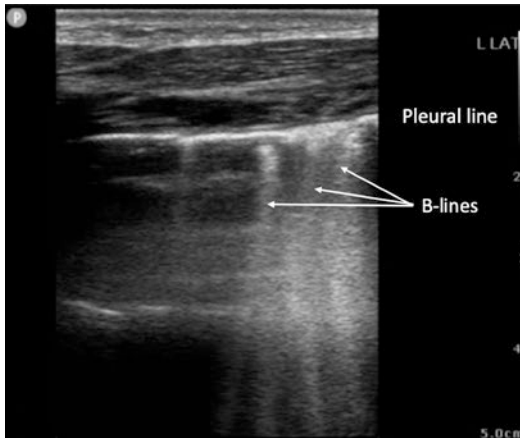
Linear probe 2D ultrasound image demonstrating B-lines
